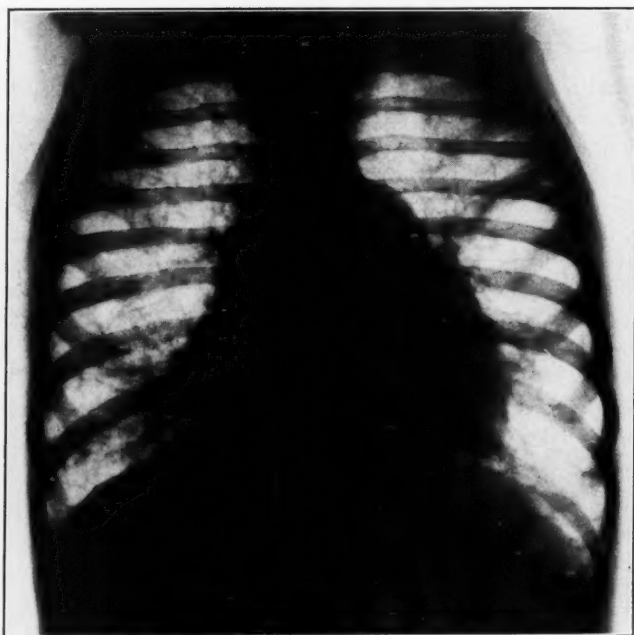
Anterior-posterior roentgenogram of the chest taken the day before death, showing enlargement of the right side of the heart and circular shadows through both lung fields. There is very little evidence of chronic bronchial inflammation.
